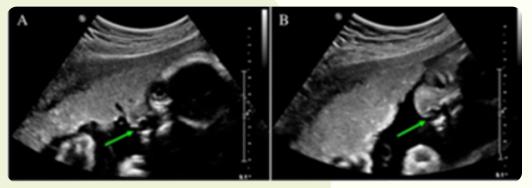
Transabdominal ultrasound of a 26 weeks' gestation. Arrows indicate cleft palate site. Retrieved from Kim, D., 2015.
